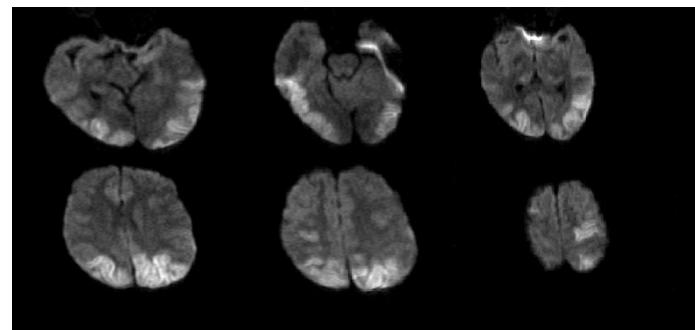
Brain MRI (DWI) showing an increase of signal in both hemispheres, predominantly in posterior zones.
